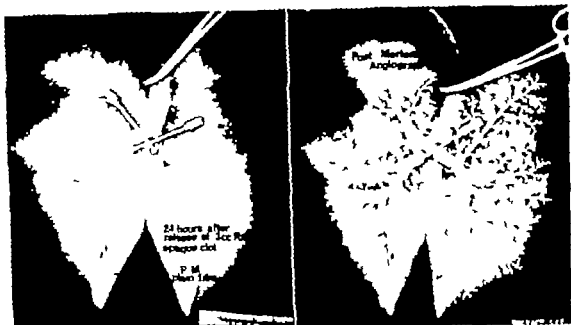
In the postmortem plain film (left) numerous radiopaque emboli are present in first-order and second-order arteries, particularly at point of bifurcation. The postmortem arteriogram (right) demonstrates flow of contrast distal to these embolic obstructions.
